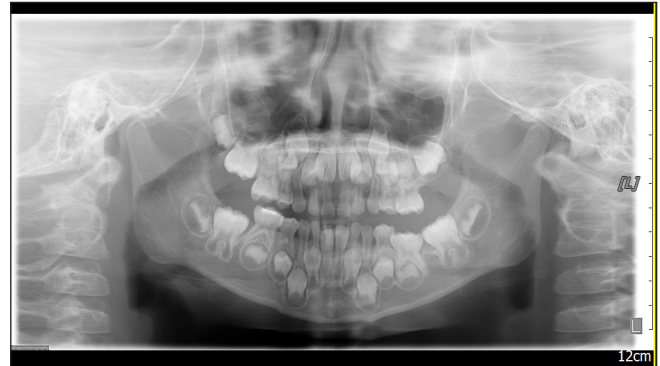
Case 1 (A) Initial intraoral view showing severe submergence of the left mandibular second primary molar. (B) Panoramic view showing the presence of all permanent successors, including a rotated mandibular left second premolar. (C) Periapical view showing complete root apices in close proximity to the developing successor crown. (D) Intraoral photograph showing spontaneous re-eruption of the submerged tooth at the 7-month follow-up. (E) Panoramic view showing that the left mandibular primary molar reached occlusal level. (F) Periapical view showing a normal periodontal ligament space. (G) Intraoral view showing that the primary molar maintained normal occlusion.
